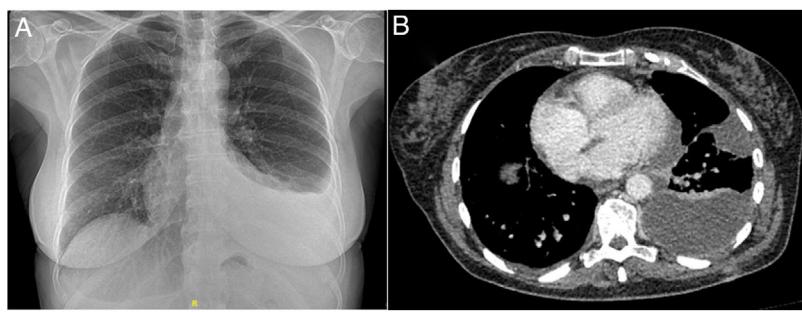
A) Chest X-ray showing left pleural effusion. B) Computed axial tomography (mediastinal window) showing free and organizing left pleural effusion.
